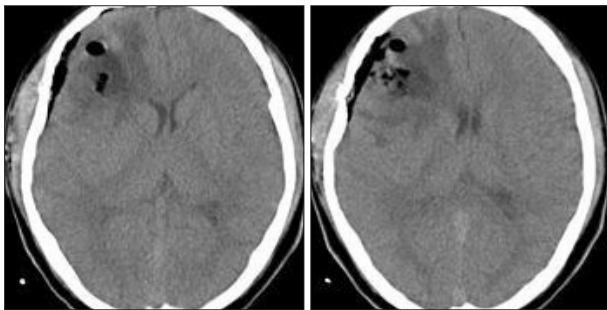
Postoperative computed tomography scans revealing nearly total removal of the hematoma.
